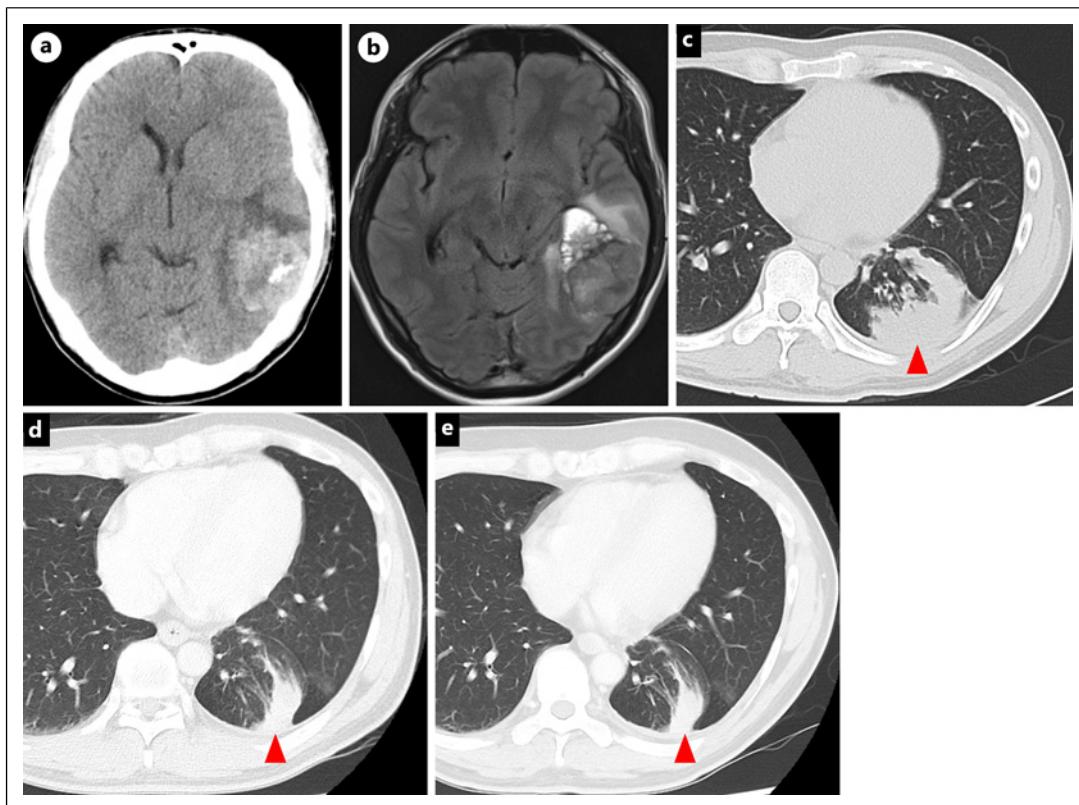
Brain CT (a), MRI (b), and chest CT (c) at initial diagnosis. Chest CT at the onset of leptomeningeal metastases (d) and 2 years after lorlatinib (e). Red arrow: primary lung lesion. CT, computed tomography; MRI, magnetic resonance imaging.
